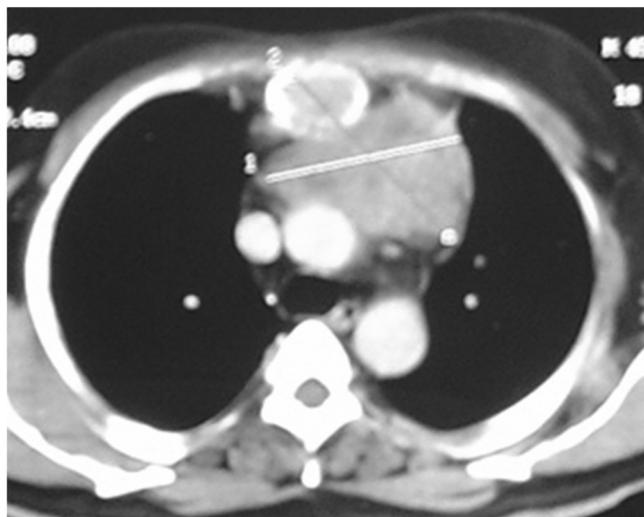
Contrast enhanced computed tomography (CECT) chest axial section showing a thymic tumor with sternal invasion.
